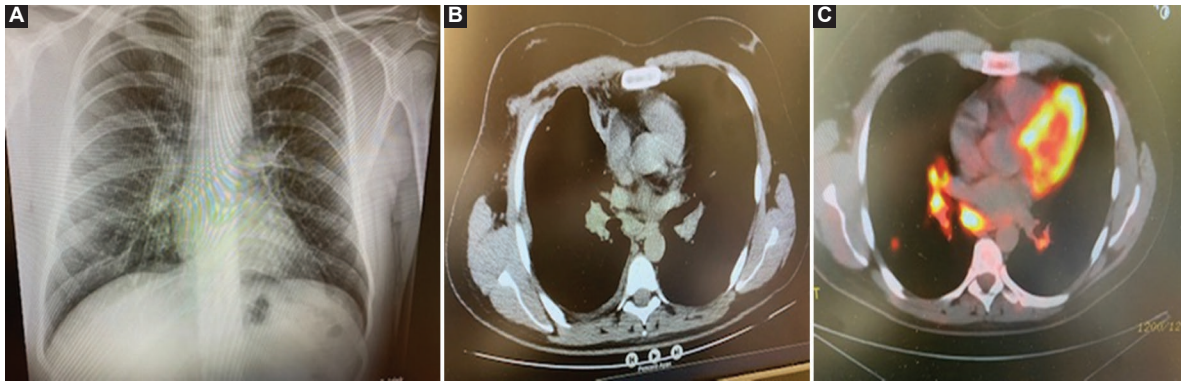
A view from the chest radiograph of the patients*. A: a section with Hilar fullness from the chest X-ray findings of the patients. B: a section from the mediastinal window view with mediastinal lymphadenopathy. C: a section with positive fluorodeoxyglucose from positron emission tomography-computed tomography findings. *It was taken from the hospital file archives of the patients in our study, and their permission was obtained.
